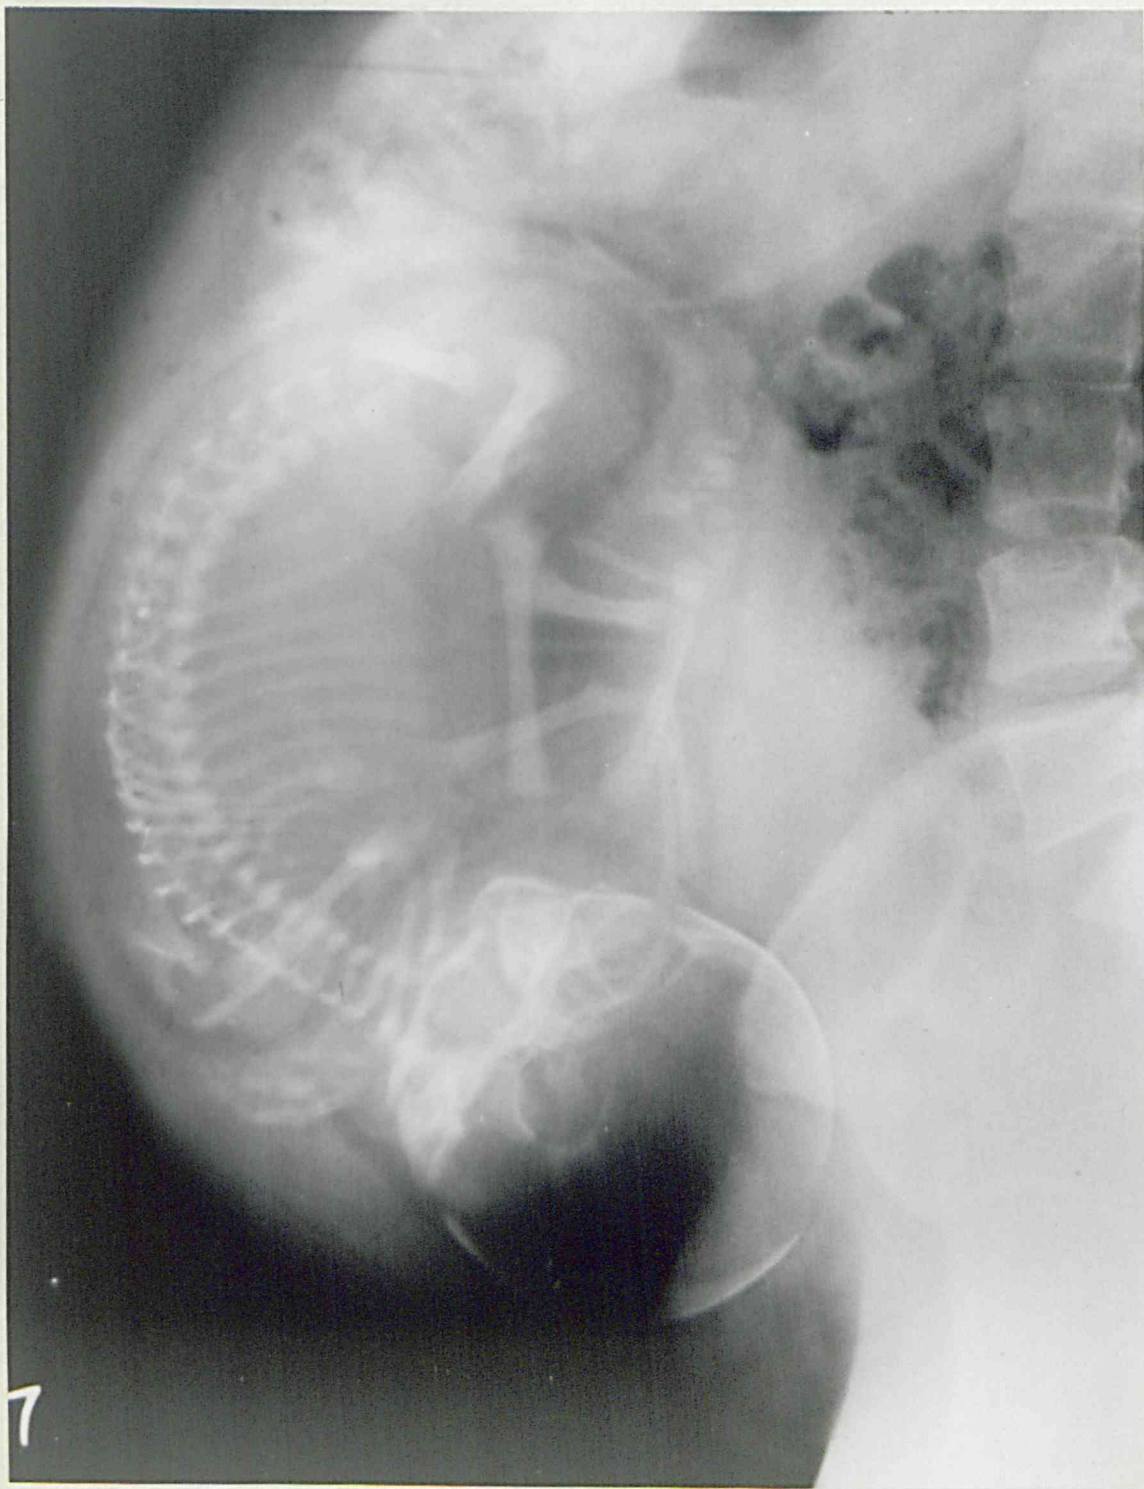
The same case as Figure 1. Soft tissue radiography demonstrates the posterior placenta praevia in the lateral view of the abdomen.
